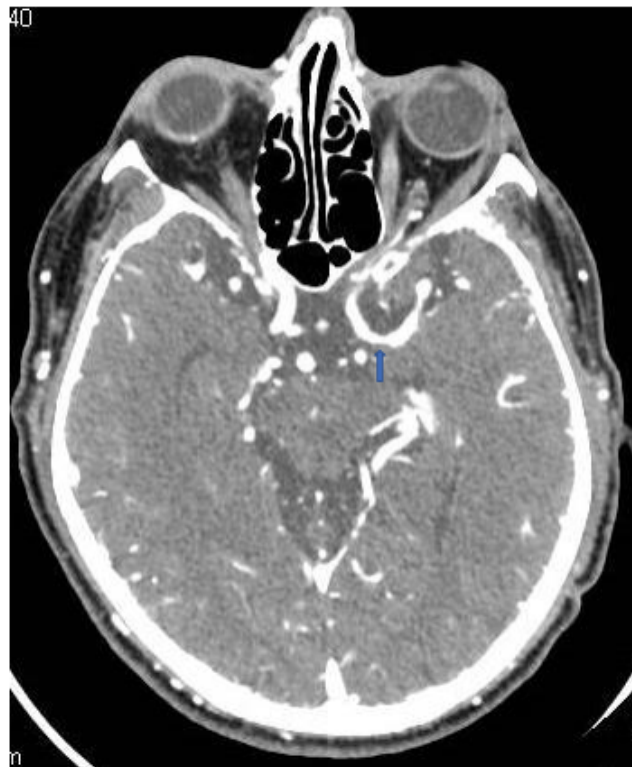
CTA at presentation: proximal MCA stenosis (blue arrowhead).
